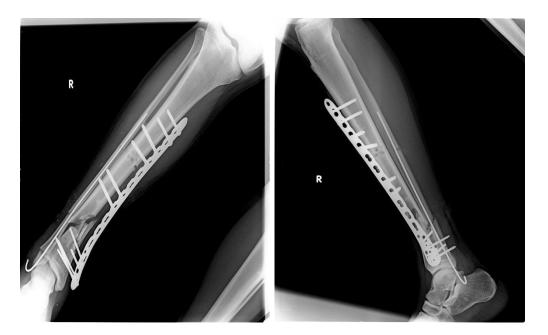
AP and Lateral radiograph of right leg at 24 weeks follow up
